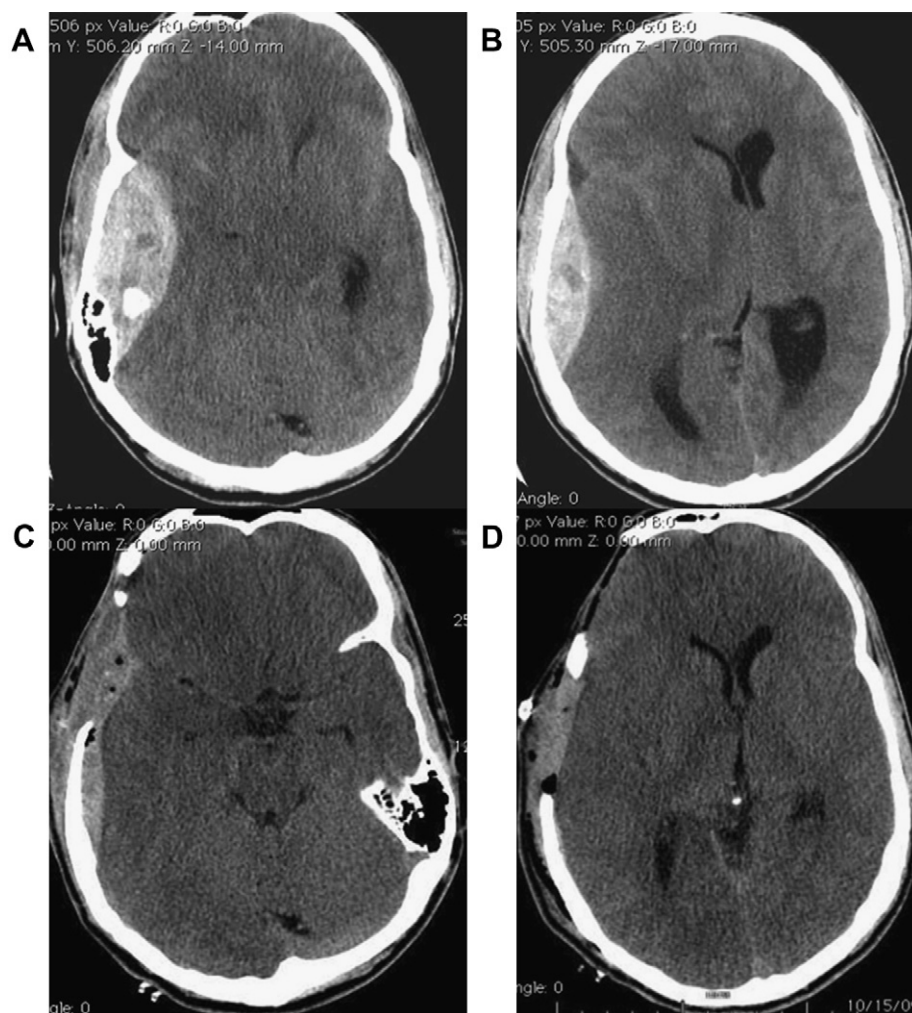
(A, B) Head computed tomography scan (HCT) showing acute right temporal epidural hematoma caused by disruption of the middle meningeal artery from a skull fracture. The patient underwent emergent hematoma evacuation and craniectomy, resolving the brainstem compression and improving the midline shift (C, D).
